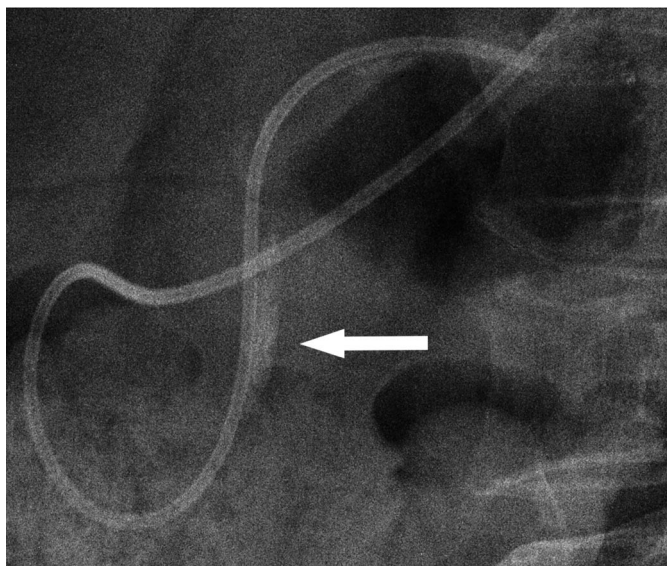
Patient 4: plain radiograph taken before the check pancreatography through the nasopancreatic drain shows an oval radiopaque foreign body in the pancreatic duct (arrow).
